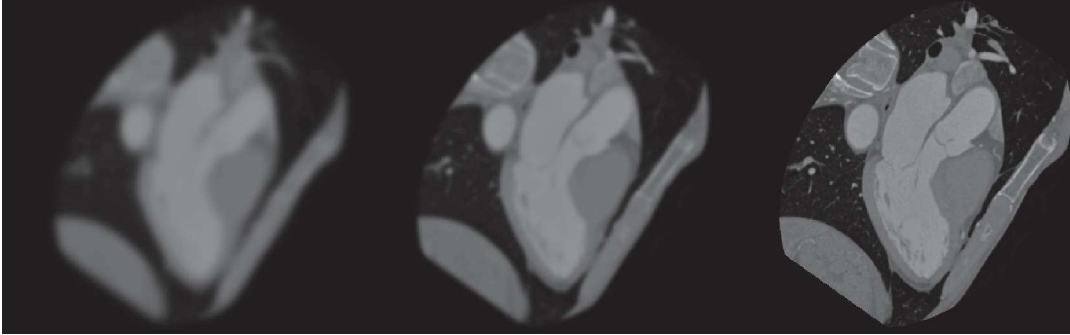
Heart image from a CT scan. Gaussian kernels applied from left to right: 3mm^3 , 1.5mm^3 and 0mm .
